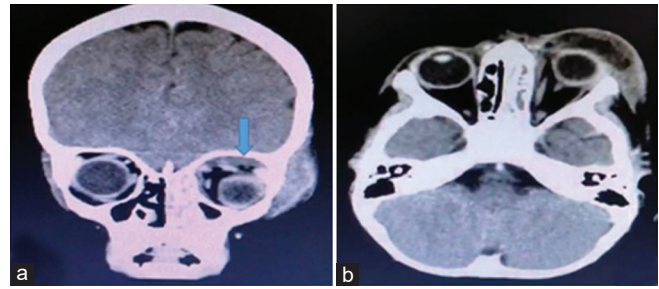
(a) Coronal computed tomography view showing left sinusitis and superior sub-periosteal abscess (arrow) (b) Axial computed tomography view showing left sinusitis and large preseptal abscess
